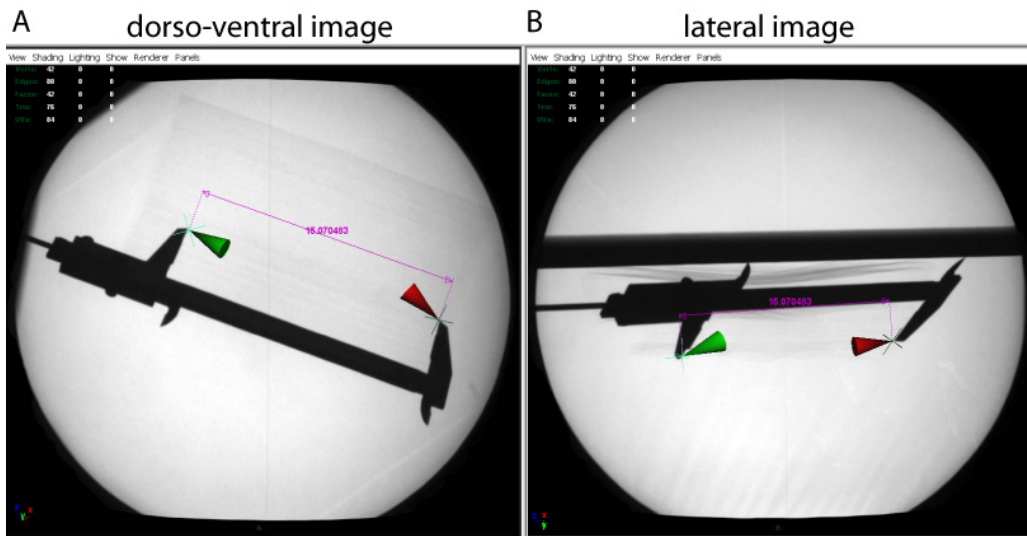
Maya™ screenshot of assessment of accuracy in measurements with re-created x-ray cameras. Outside jaws of a vernier caliper were opened to exactly 150 mm. The caliper was randomly positioned within the visible field of both x-ray cameras. X-ray data was processed in the same manner as the sloth recordings of this study (i.e., un-distortion of images, calibration of 3-D space, and recreation of x-ray cameras in Maya™). Then, two cones were created and the tips of the cones were oriented in 3-D space to virtually touch the tips of the outside jaws of the caliper in both projections. The distance between the tips of the cones was finally measured using the distance measurement tool of Maya™.
